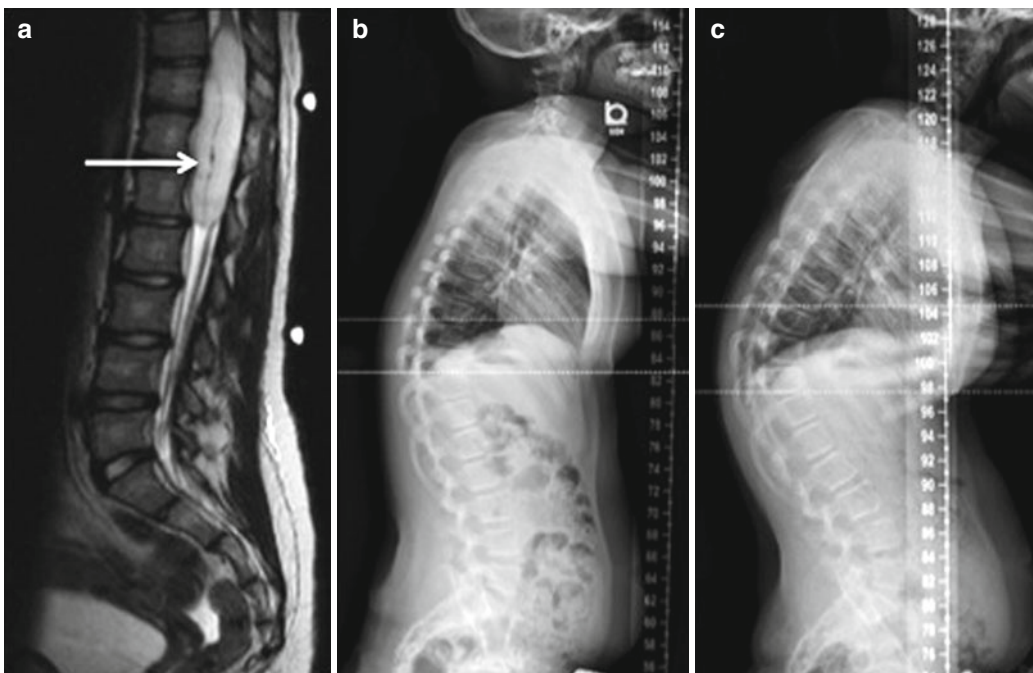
(a) Preoperative sagittal MR image showing tumor (arrow). Postoperative lateral radiographs taken at (b) 2 weeks and (c) 6 months. Note the progressive iatrogenic kyphosis that has developed
